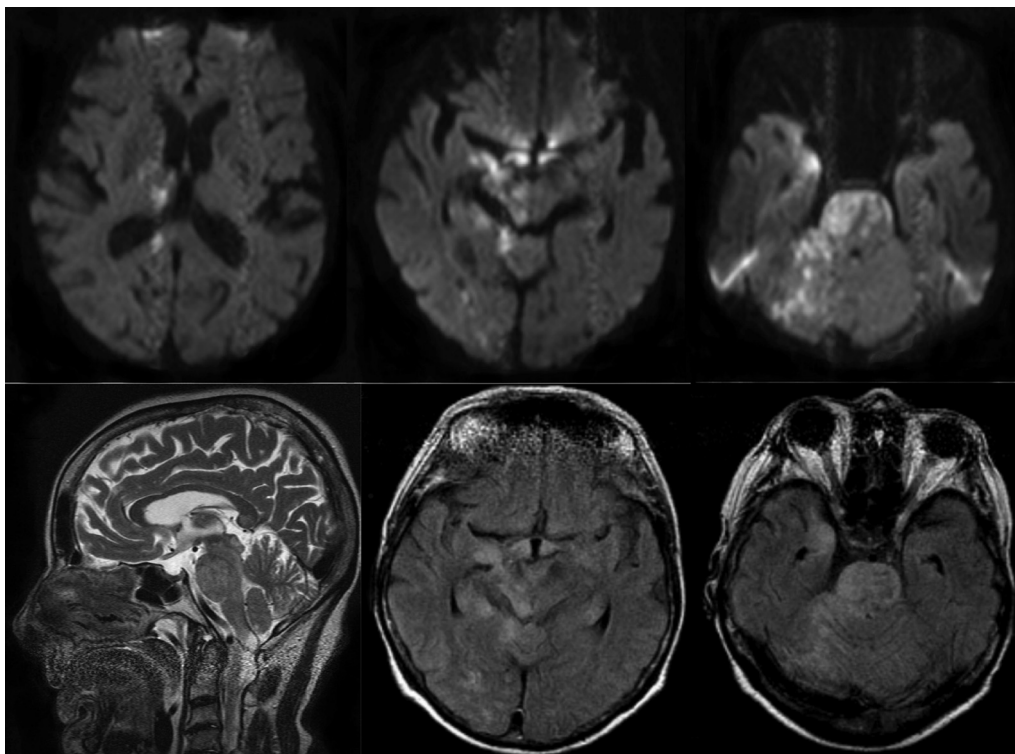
(Top) Magnetic resonance imaging shows multiple lesions (intracellular edema) on diffusion-weighted sequences, mainly in the right frontal, occipital, temporo-occipital, and thalamic regions as well as in the pontine area and right cerebellum. Time-of-flight angiography (not shown here) was normal without signs of vascular pathology. (Bottom Left) The T2-weighted midsagittal plane showing signal enhancement of the pons compatible with a brainstem edema. (Bottom Right) Fluid attenuated inversion recovery showing an intercellular edema of the brainstem, with the involvement of the right cerebellar hemisphere and the mesial temporal lobe including the corpus amygdaloideum. Midbrain on the right side is affected as well.
